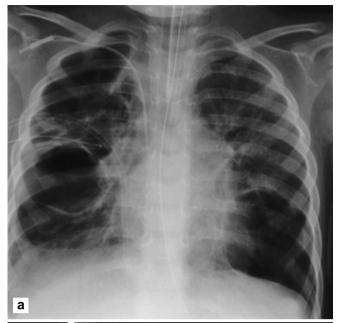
a Bilateral *Streptococcus pneumoniae* pneumonia in a 2-year-old girl. Chest radiograph shows three to four cavities in the right lung. b Axial CT scan of the same child shows multiple thinwalled cavities within the anterior and apical segments of the right upper lobe (RUL; *arrows*). The posterior segment is totally consolidated. The patient underwent surgical resection of the RUL
